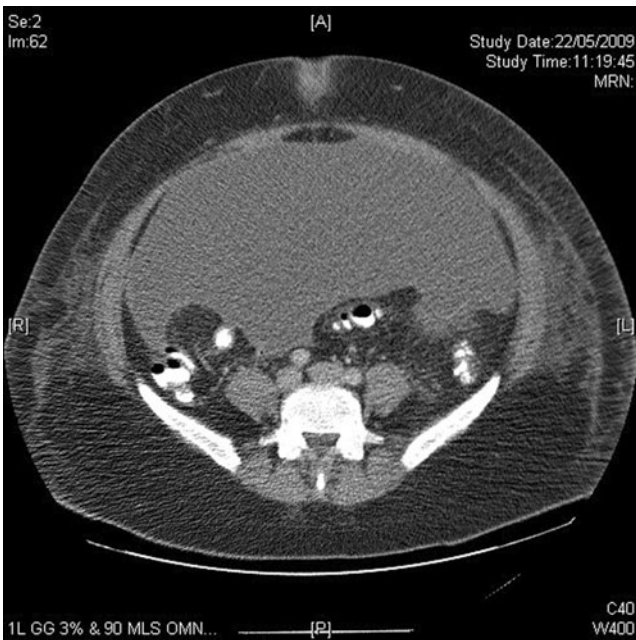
Abdomino-pelvic computed tomography at initial presentation.
